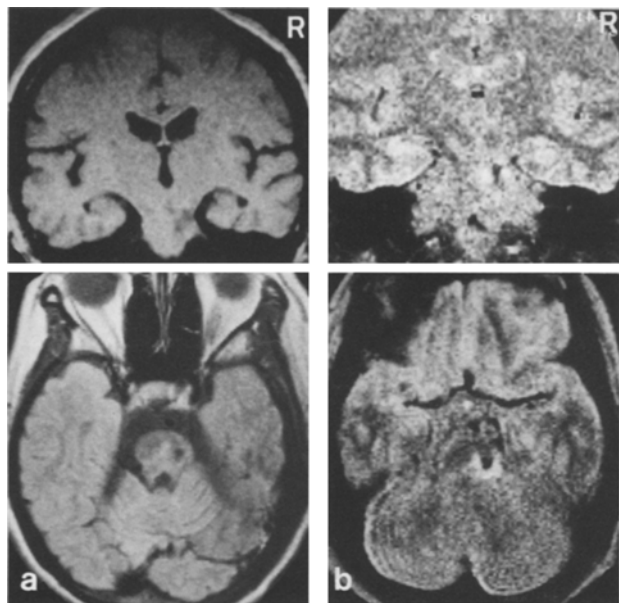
MRI of case 1 17 months after the onset of clinical symptoms. The left row (a) shows T1-weighted images (TR = 600 ms, TE = 35 ms). The right row (b) shows T2-weighted images (TR = 1600 ms, TE = 70 ms). a A low signal lesion is seen in the right pons. b A low signal lesion with marginal high signal area is noted in the right pons, suggesting a liquefying necrosis with surrounding gliosis
